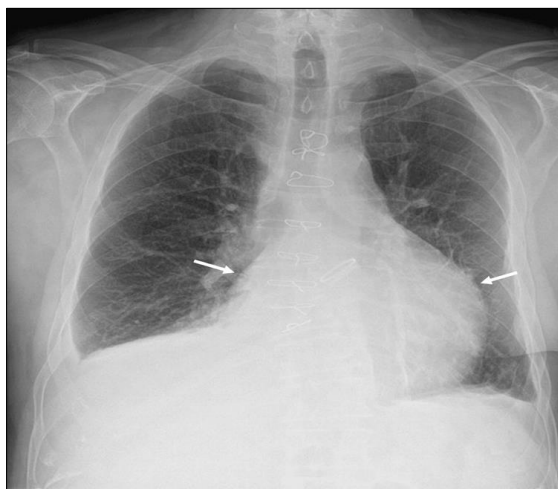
Posteroanterior chest radiograph demonstrating enlarged cardiac silhouette in a patient with prior sternotomy (sternal wires visible). No overt pulmonary edema is present. Arrows indicate the enlarged cardiac silhouette, which is suggestive of a large pericardial effusion
